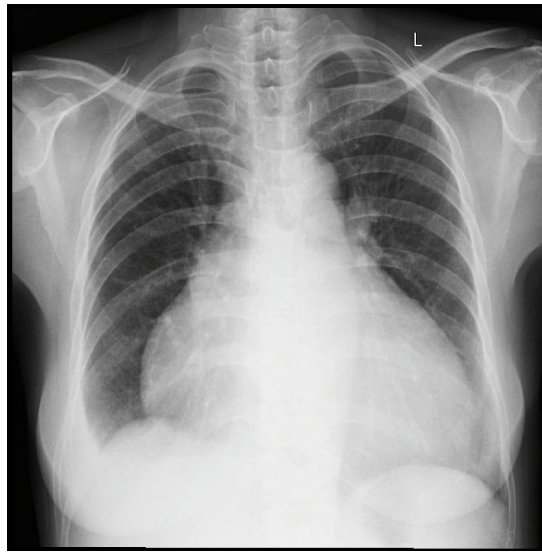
Preoperative chest X-ray showing cardiomegaly and pulmonary edema
